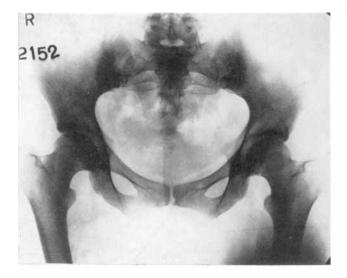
CASE 4. X-ray photograph showing tuberculosis of symphysis publs—before pregnancy commenced.
